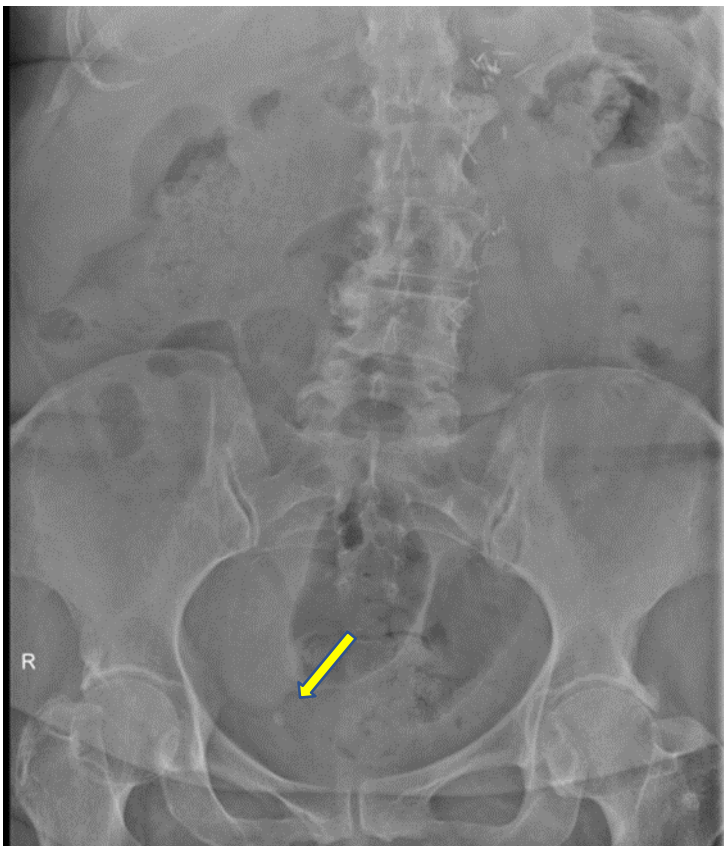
Simple abdominal X-ray. There is a calcium image in the right minor pelvis which is suggestive of right juxtavesical lithiasis (arrow)
